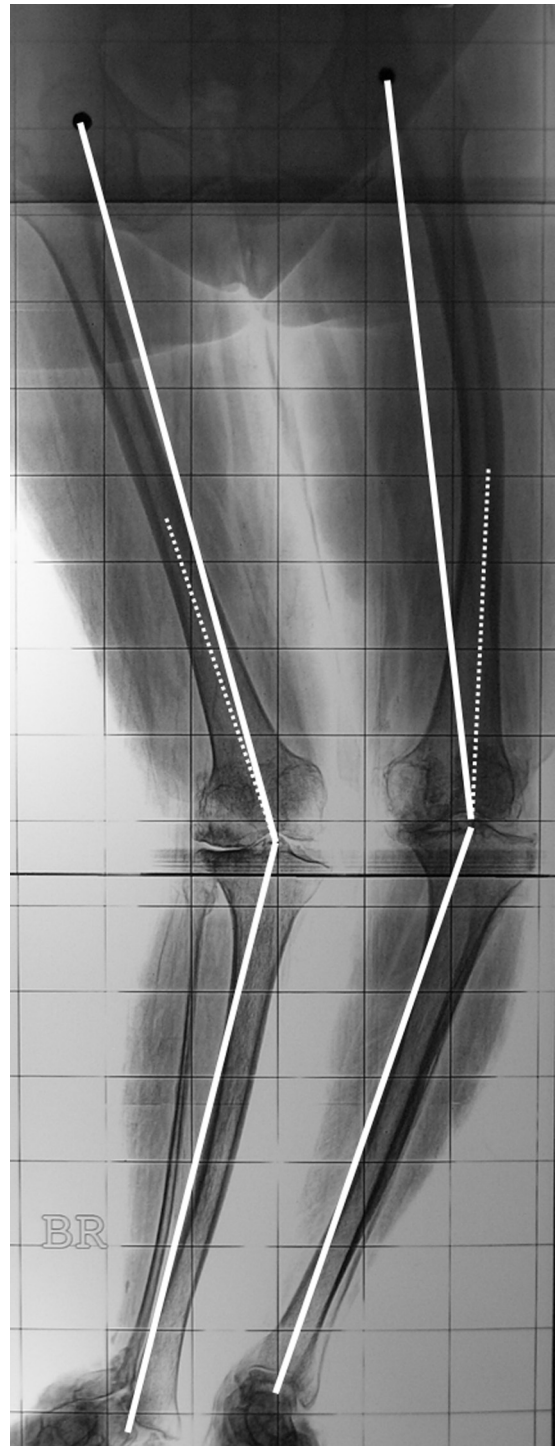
Preoperative standing, full-length hip-to-ankle radiograph in a 76 year old female patient showing significant windswept deformity with a femoral valgus correction angle (VCA) of 4° for the right side with valgus deformity and VCA of 11° for the left side with varus deformity.
